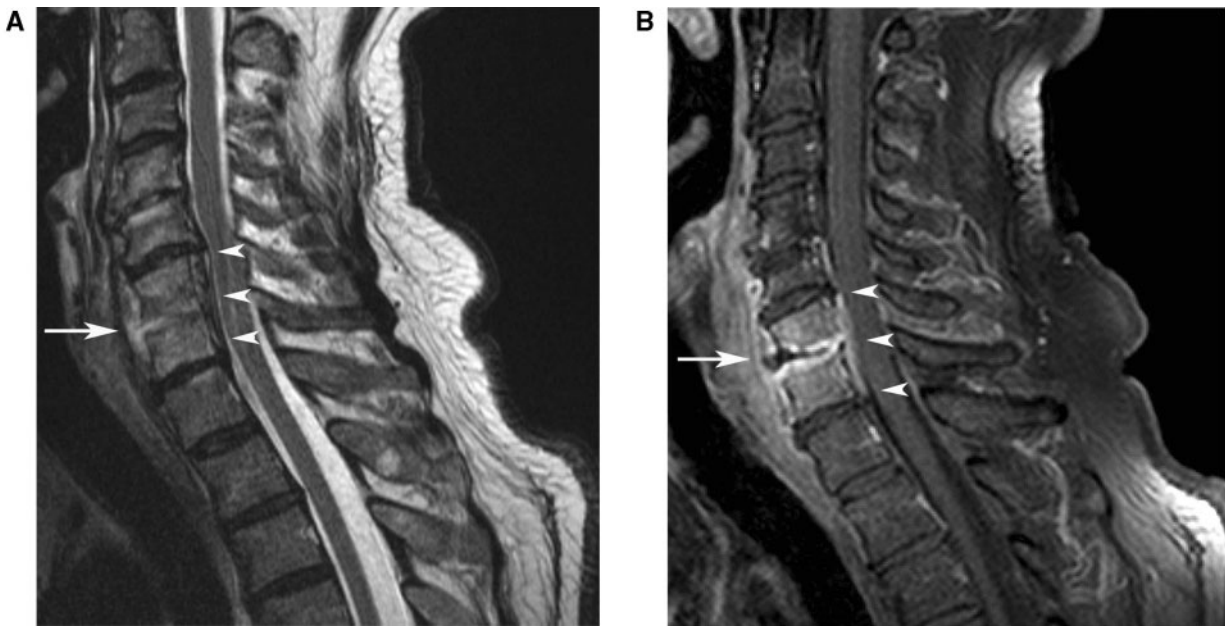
MRI. T2-weighted image (A) and T1-weighted fat-saturated image after intravenous gadolinium (B), showing spondylodiscitis (arrow) complicated by an SEA at the C6–7 level (arrowheads).
